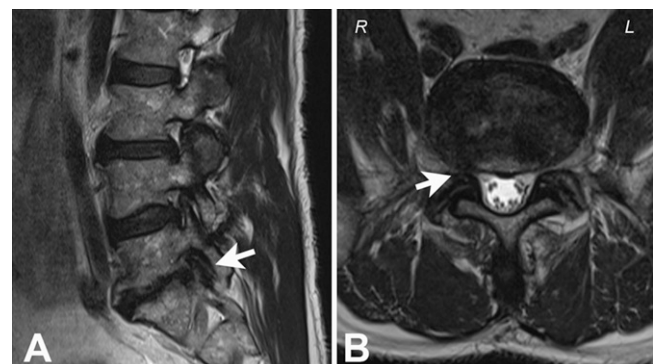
A: Lumbar MRI (sagittal view) that revealed severe right foraminal stenosis (arrow) compressing the L5 nerve root. B: Axial view showing severe right foraminal stenosis (arrow).
